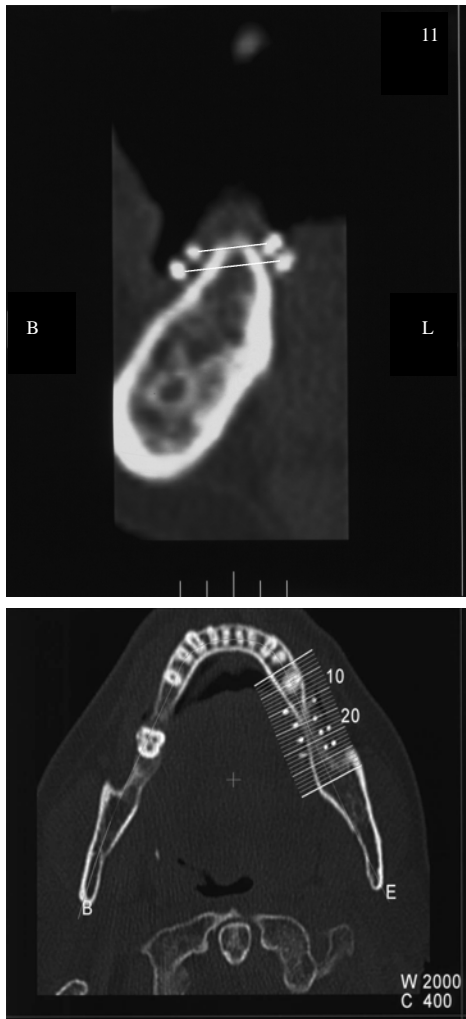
Spiral CT of mandible with gutta-percha markers
